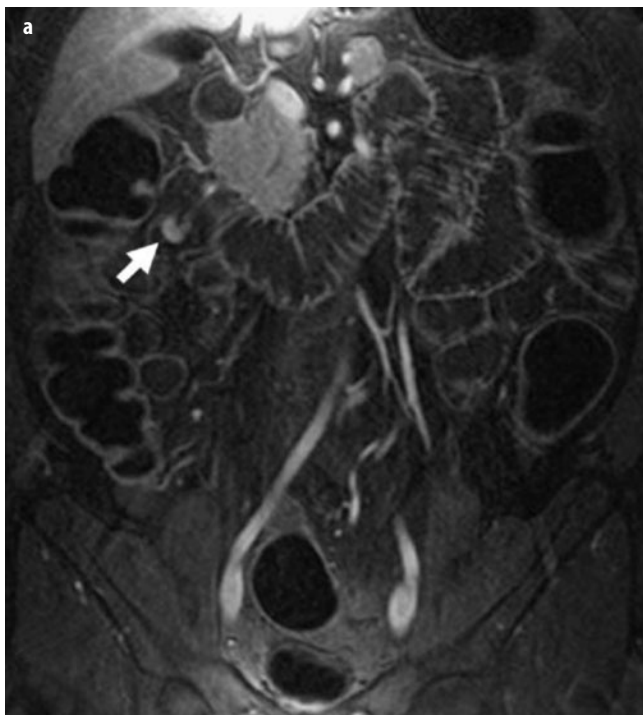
a, b. Small-bowel carcinoid tumor (neuroendocrine tumor): magnetic resonance (MR) enteroclysis following biphasic luminal contrast application (methylcellulose). a T1-weighted gradient-echo (GRE) postcontrast images in coronal plane demonstrate very good distention of the entire small bowel, allowing detection of a 1.1-cm intraluminal polypoid lesion with enhancement located in the mid ileum, right upper quadrant (*a arrow*). b Magnified view better delineates the bean-shaped mass with vivid enhancement (*arrow*). There is no associated lymphatic spread or desmoplastic reaction in the mesentery. Note the mesenteric desmoplastic reaction, a characteristic feature of carcinoid tumors of the small bowel, may be absent in up to 25% of cases [22] when the tumor is small
